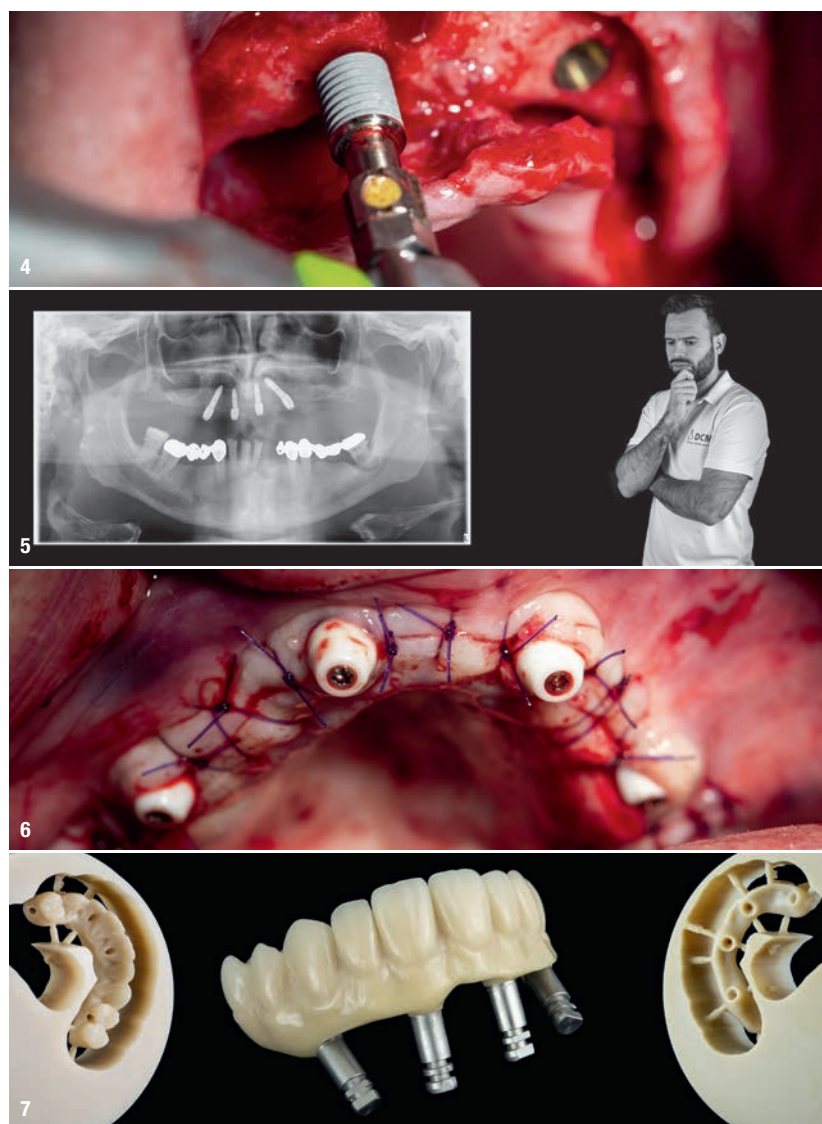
Surgical procedure, placement of implants. Fig. 5: CT scan after the surgical insertion of the four implants. Fig. 6: Result immediately after surgery. Fig. 7: Alpha-bridge: initial temporary design.
